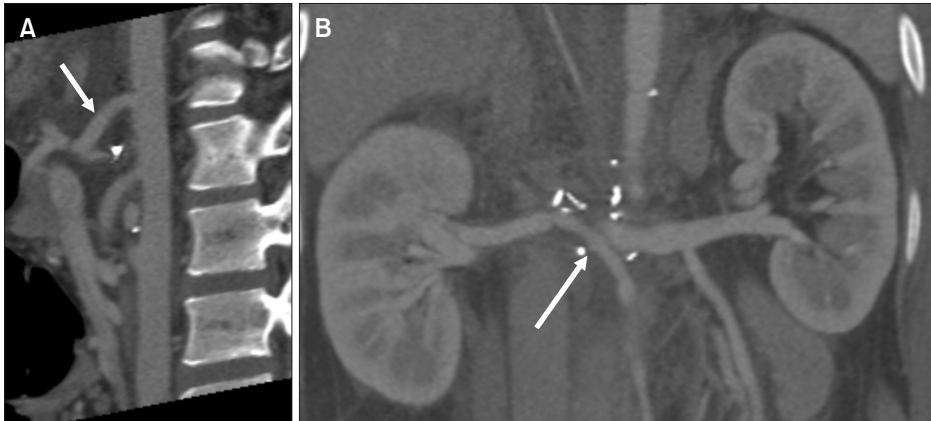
Postoperative computed tomography images. (A) The sagittal view showed the patent aorto-common hepatic artery bypass graft (arrow). (B) The coronal maximal intensity projection image showed the patent aorto-renal bypass graft (arrow).
